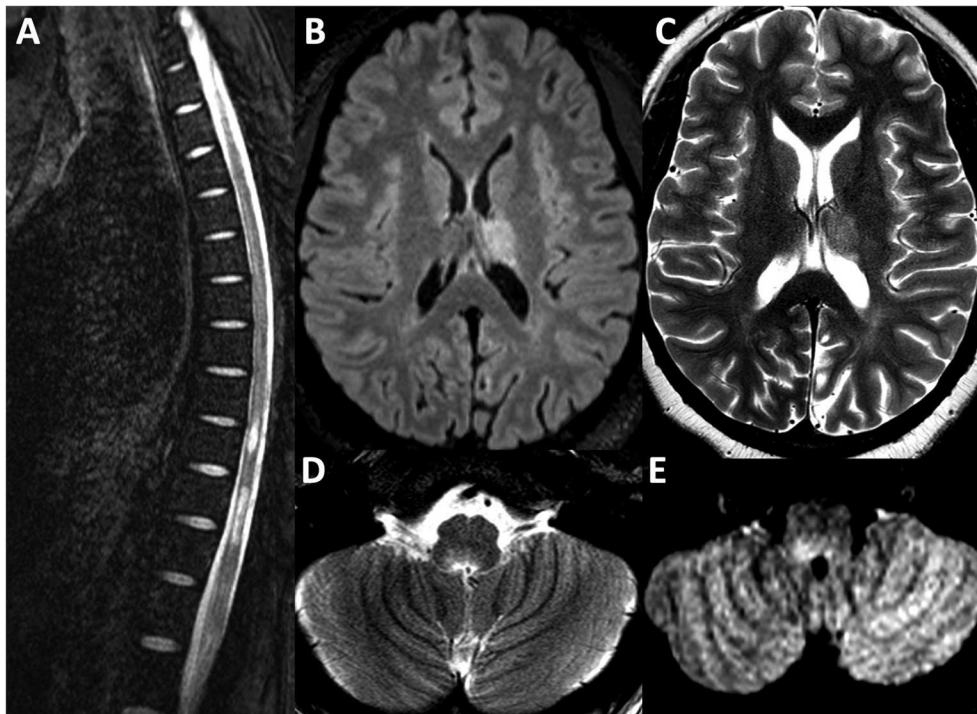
MRI Brain sequence from the second attack in 2019. (A) T2 weighted sequence depicting longitudinally extensive transverse myelitis from T7 to L1, associated with mild cord expansion. Lesions depicted affecting the left thalamus are depicted in the T2-FLAIR sequence in (B) and the T2 weighted sequence in (C). A new right ponto-medullary lesion is visualized on the T2 weighted sequence in (D) and T2-FLAIR sequence in (E).
